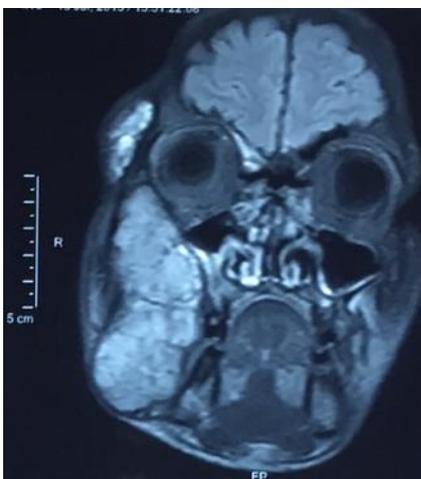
MRI: a right temporo-jugal lesion process
